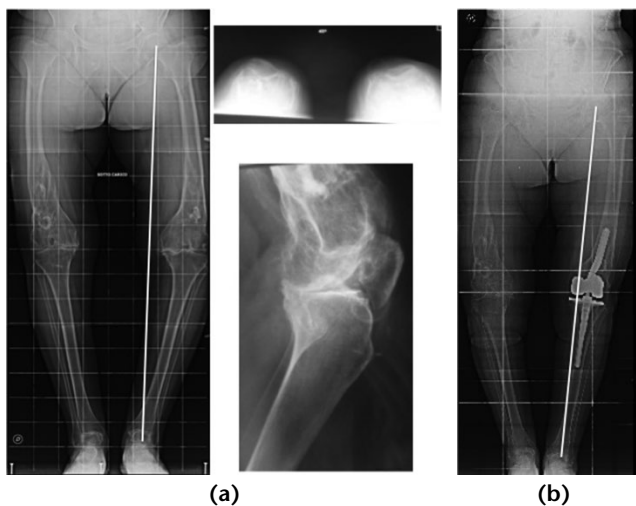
a) Extra-articular deformity: pre-operative condition. b) Post-distal femoral fracture and follow-up at 3 years after CCK implant. Radiographs show good restoration of limb alignment.
